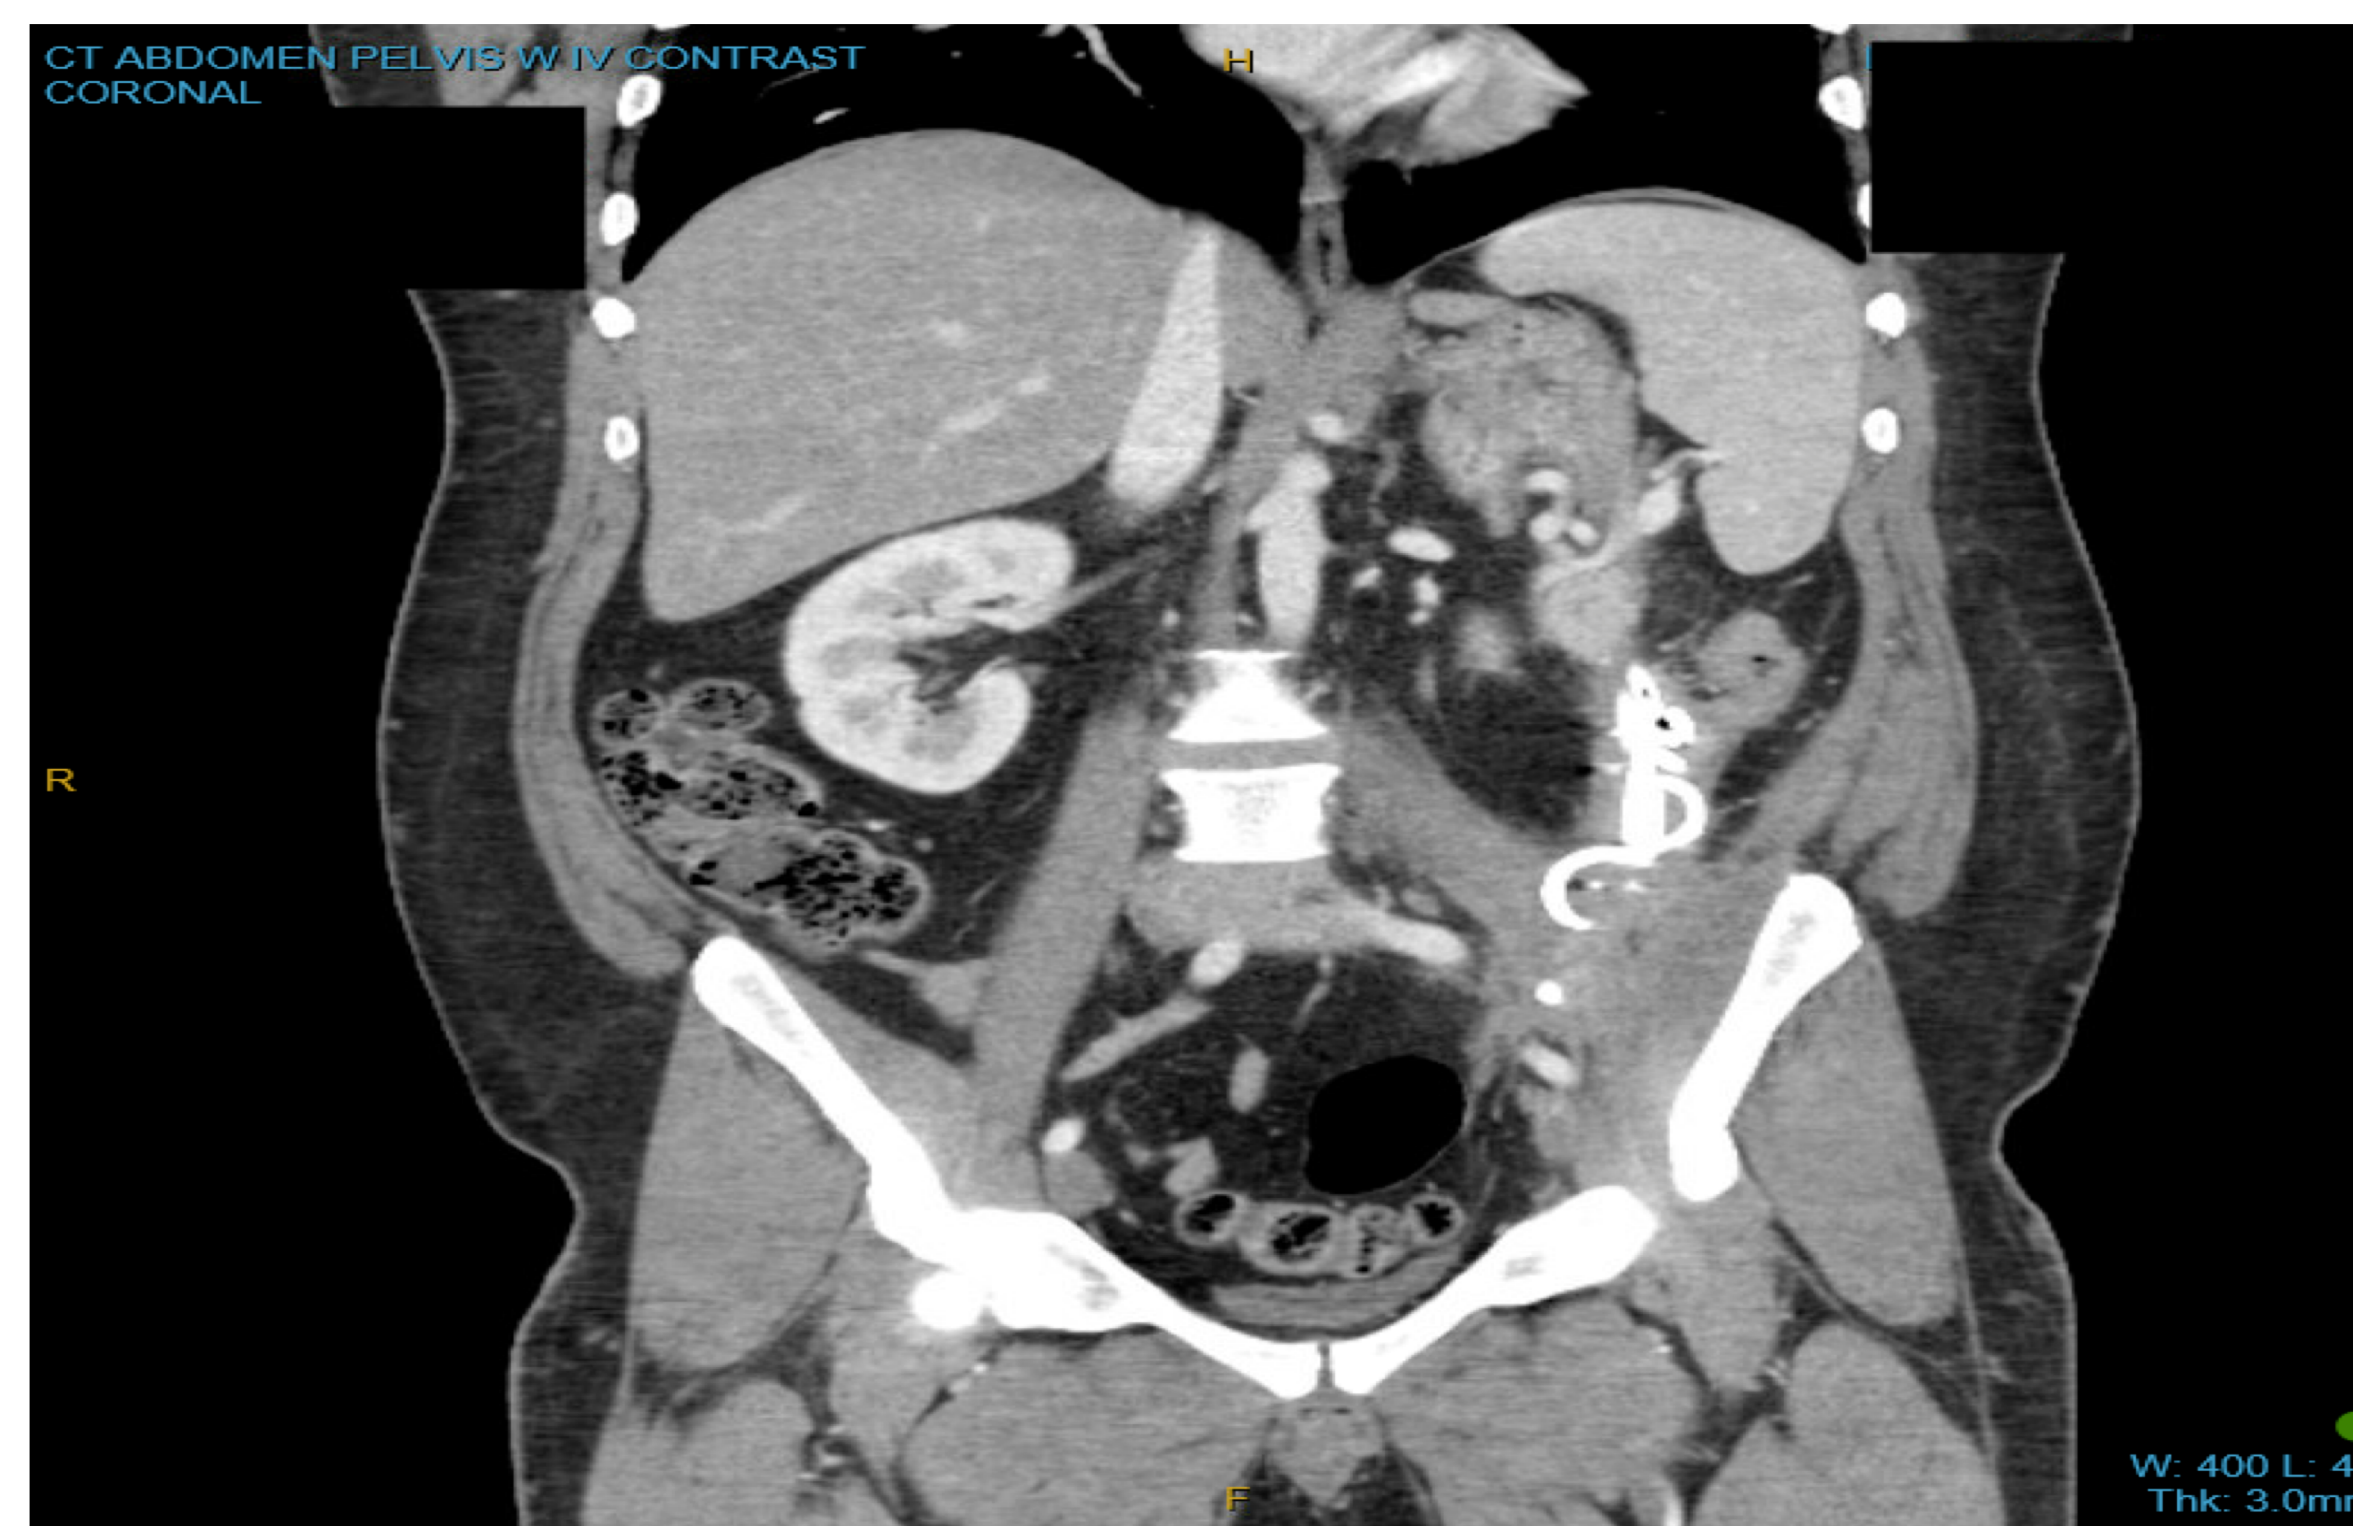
Coronal (top) and Axial (bottom) view of the CT A/P showing a CG DP plastic stent adjacent to the L flank musculature.
